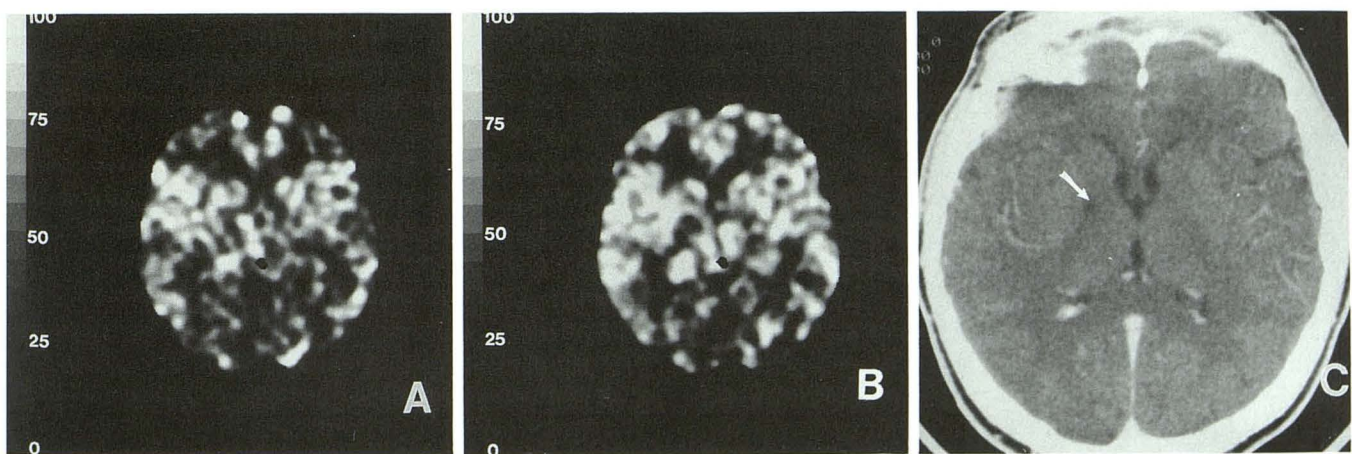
Case 3. The unoccluded baseline xenon CT CBF study demonstrated normal symmetric CBF (A), which did not appreciably change with temporary right ICA occlusion (B).
